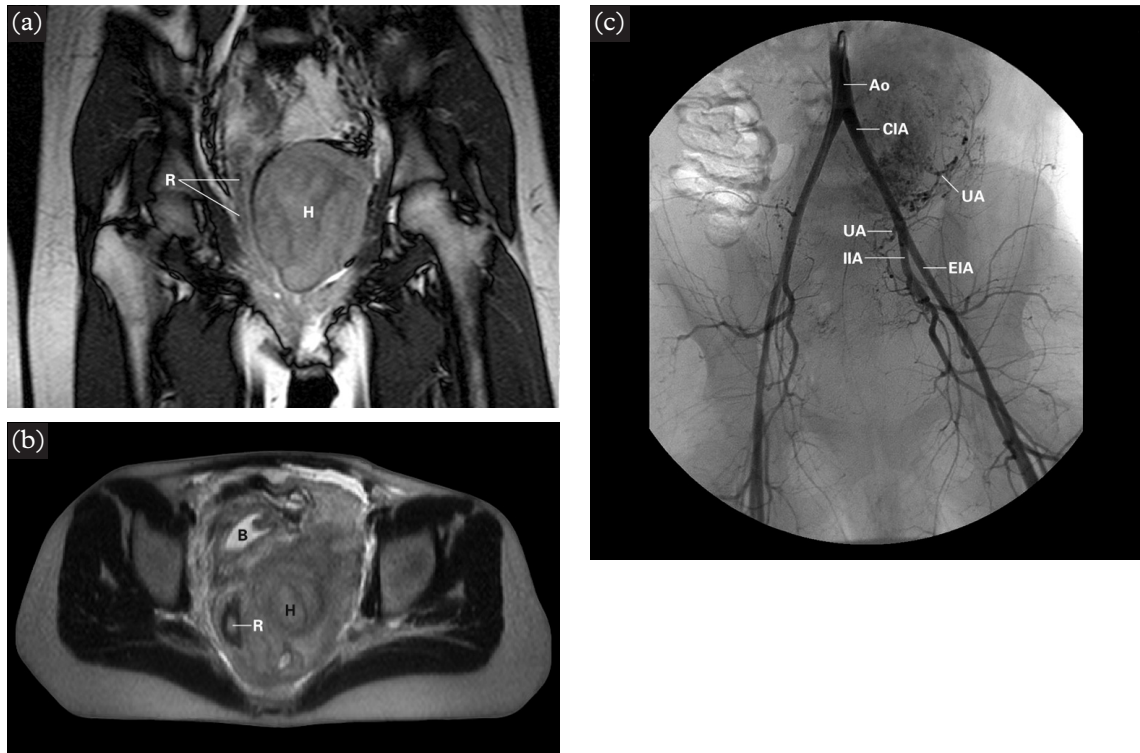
Case study: a 23-year-old woman, who had been diagnosed to have double uterus and double vagina, with the right uterus having been removed several years before. Following vaginal delivery at full term weeks, she became anemic, with the hemoglobin measuring approximately 6.0 g/dl. Intrapelvic pain was reported, mainly on the left. Hemorrhage per vagina was only of a moderate degree. (a and b) T2-weighted magnetic resonance images of the pelvis, in coronal (a) and axial (b) cross-sections. A hematoma (H) is detected in the left pelvic floor. The right side of the pelvis is preserved. R, rectum and adjacent tissue; B, bladder. It was anticipated that left-sided embolization would achieve hemostasis based on these images. (c) Whole pelvic arteriography. The right common femoral artery was punctured and a 5 French gauge hook-shaped catheter was inserted to the distal aorta (Ao) where radiological contrast was infused. The outline of the common, internal and external iliac arteries (CIA, IIA and EIA, respectively) and their major branches are demonstrated. The intramural branches of the uterine artery (UA) distribute both above and within the pelvis. The hematoma is shown as a relatively hypovascular zone (H). (d) Left internal iliac arteriography in the left anterior oblique position (LAO). Identification of the uterine and vaginal arteries (UA and VA, respectively) is achieved: the origin of the uterine artery (UAO) is shown. The superior and inferior gluteal trunks are superimposed (*). This falls into the category of vascular anatomy shown in Figure 1b. A 5 French cobra-shaped catheter is used. (e) Left uterine arteriography. Superselective catheterization was achieved using a 3 French gauge catheter inserted through the 5 French cobra-shaped catheter. The intramural branches with their characteristic tortuosity are shown. Although no extravasation is demonstrated, unilateral and partial embolization using grated particles of gelatine sponge was performed in view of increased hemorrhage per vagina and the anatomical communication between the uterine artery and the arteries to the upper vagina. (f) Left vaginal arteriography. Extravasation is clearly revealed (arrowheads) on hand injection of radiological contrast through the 3 French catheter (arrow). Embolization was performed using grated particles of gelatine sponge until the extravasation was barely detectable. (g) Left inferior gluteal arterial trunk post-embolization. The uterine artery (UA) and a smaller number of its intramural branches are opacified, the vaginal artery and the branches to the hematoma are no longer opacified. Following embolization, the hemorrhage per vagina reduced to within normal losses; hemoglobin increased to 11 g/dl on the next day and 12 g/dl on the following day. The patient was discharged 2 days post-embolization without undergoing any other intervention; outpatient follow-up confirmed satisfactory recovery
